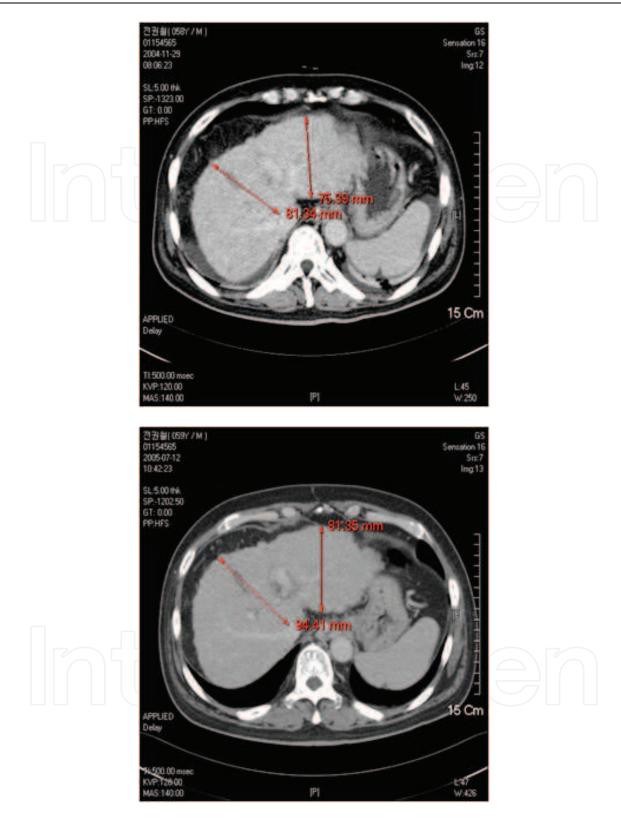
CT findings from the patient who is living more than 5 years. A is CT taken just before (Feb. 21, 2005) stem cell therapy and B is CT taken was after 5 months (July 23, 2005). The measured liver size was increased from 689.98 CC to 915.36 CC and hepatic density is lowered suggesting release of fibrosis.
